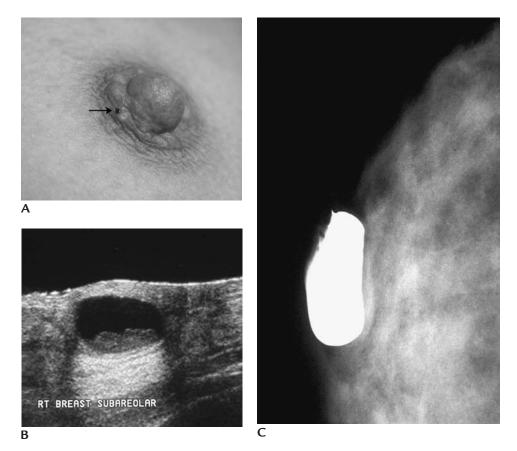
Montgomery's gland. (A) Discharge arising from a Montgomery's gland (*arrow*). (B) Ultrasound at the site of the discharge demonstrates a complex cystic mass associated with the dermal layer and causing a smooth contour deformity of the skin at this site.
